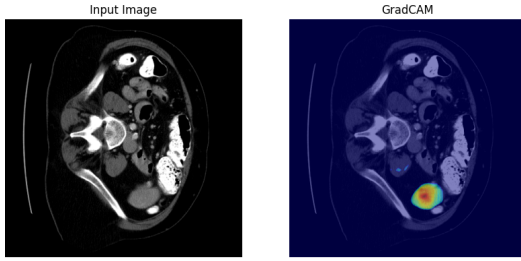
Grad-CAM visualization showing the network's attention regions on a spleen CT slice
